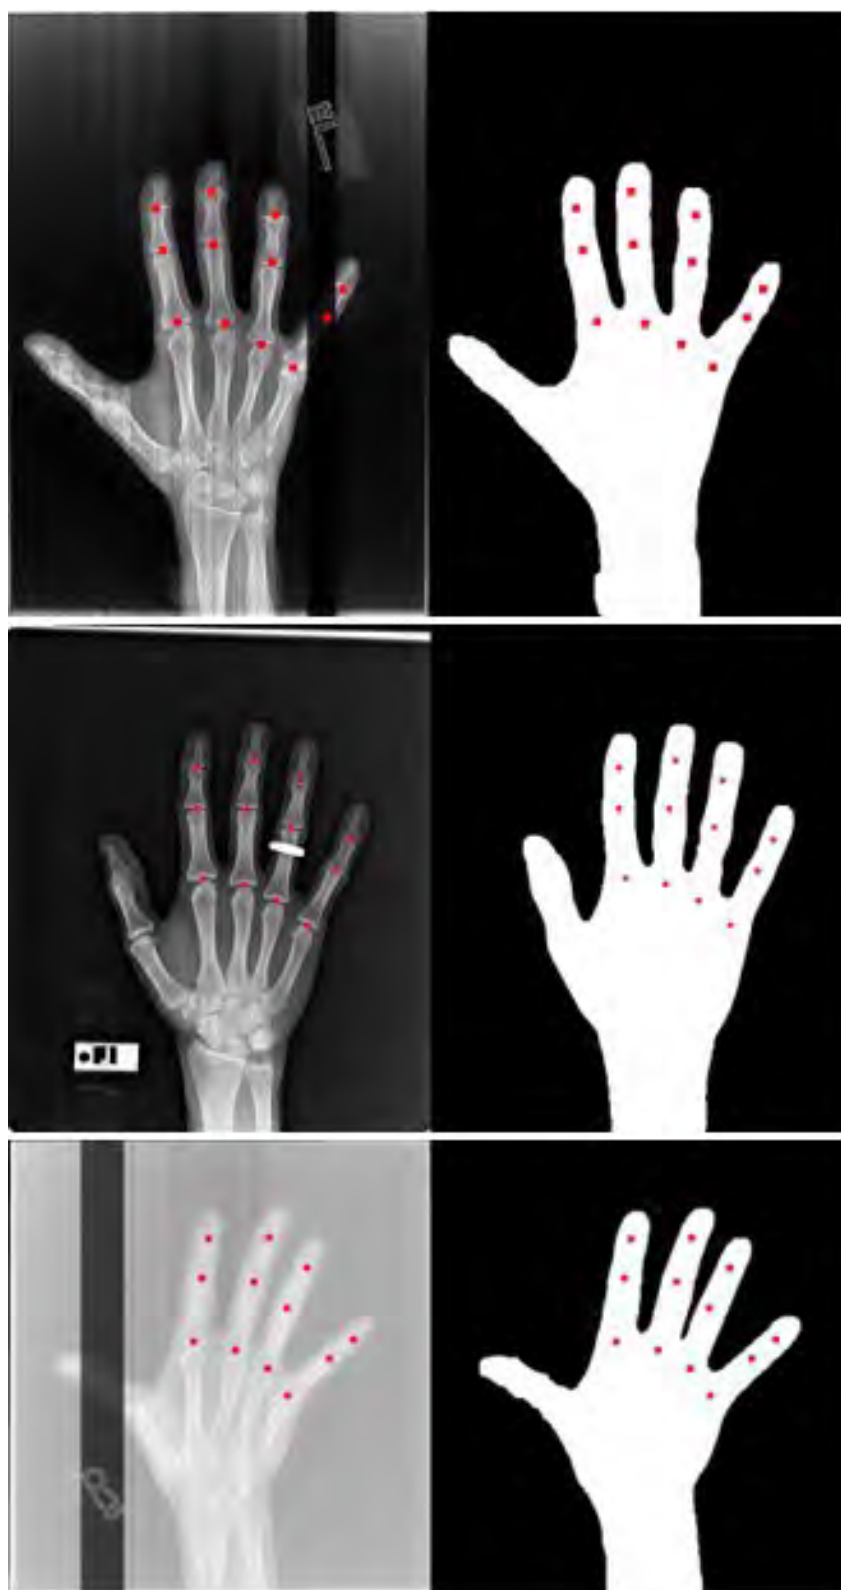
The first column contains challenge hand X-ray images with white bands, rings, and low contrast. The red dots are manual marks of 12 joint centers. The second column is the predicted hand masks by the machine learning model U-net (model 3).
